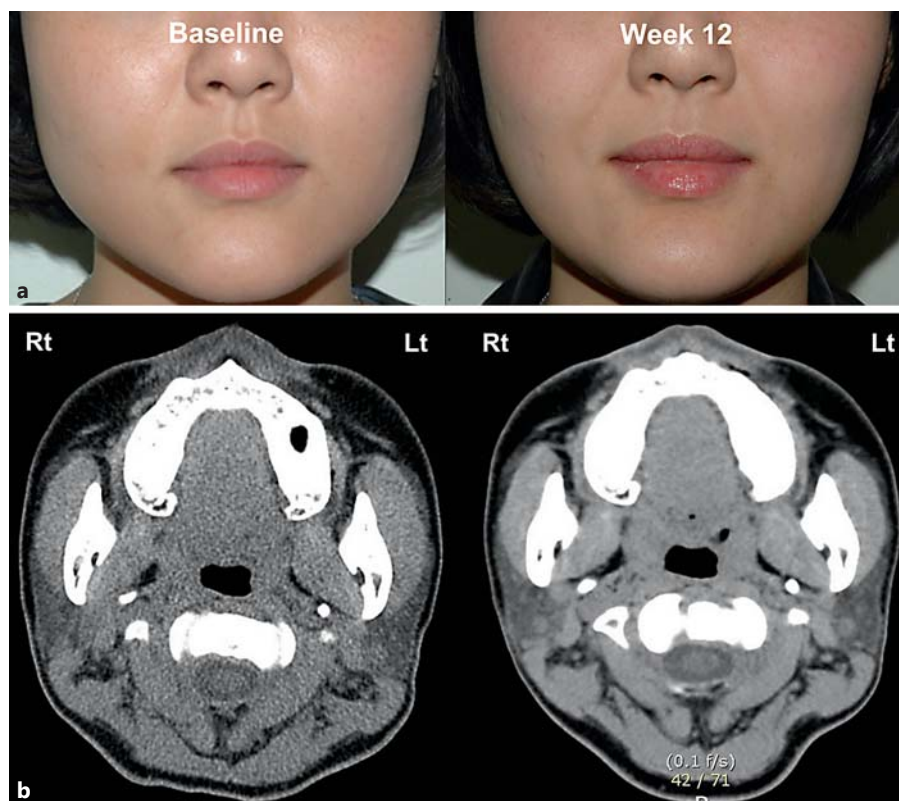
Representative digital photographs and CT images showing differential improvements during the study. The left masseter of this woman's face was treated with BTX-A and the right with BTX-B. Both botulinum toxins produced remarkable improvements in masseter hypertrophy. The muscle volumes of the right and left masseters were determined; the former exhibited an 87% reduction and the latter an 83% reduction of the original (baseline) volume. a Clinical photographs. b CT images.
